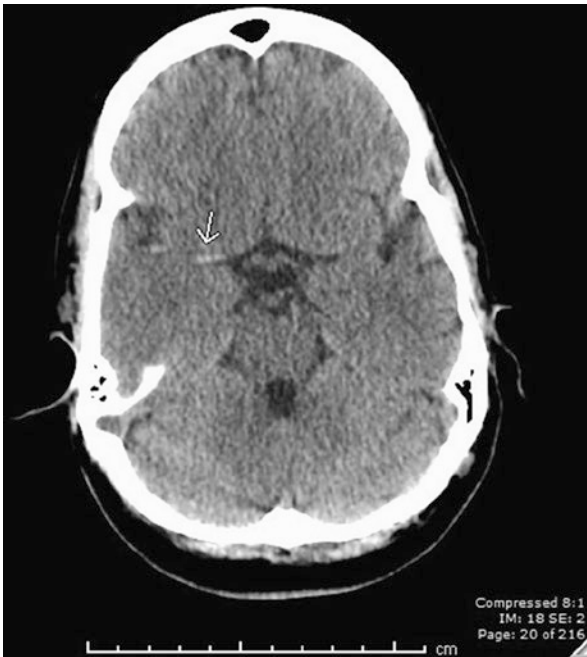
Non-contrast head CT demonstrating a hyperdense right middle cerebral artery
